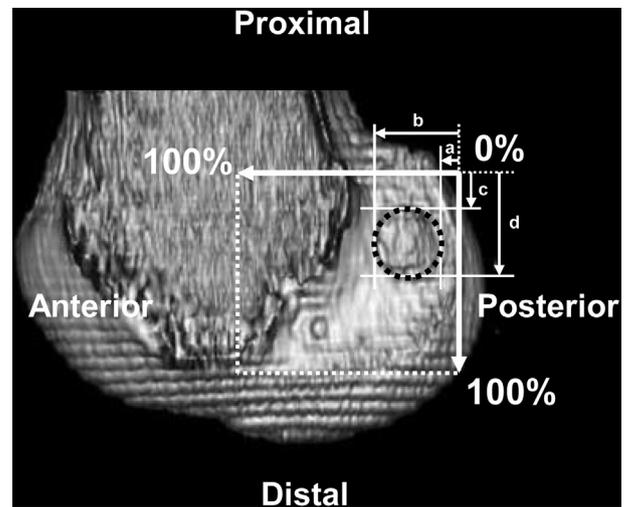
Computed tomography image of the distal femur showing the measurement of the location of the femoral tunnel walls using the anatomical coordinate system [23,30,31]. The black dashed line indicates the femoral bone tunnel. The distance from the posterior border of the medial wall of the femoral lateral condyle to the most anterior point of the notch was defined as 100% for the anterior–posterior measurement, while the distance from the proximal border of the notch to the distal point of the notch roof was defined as 100% for the proximal–distal measurement. (a), (b), (c) and (d) are the positions of posterior, anterior, proximal and distal tunnel walls, respectively. The tunnel wall positions in the anterior–posterior and proximal–distal directions were calculated as percentages of these distances.
